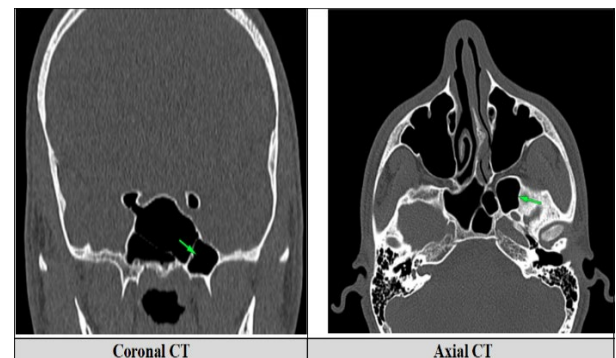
Coronal and axial CT demonstrating a left-sided sphenoid sinus lateral recess. *Green arrow (left-sided lateral recess).
